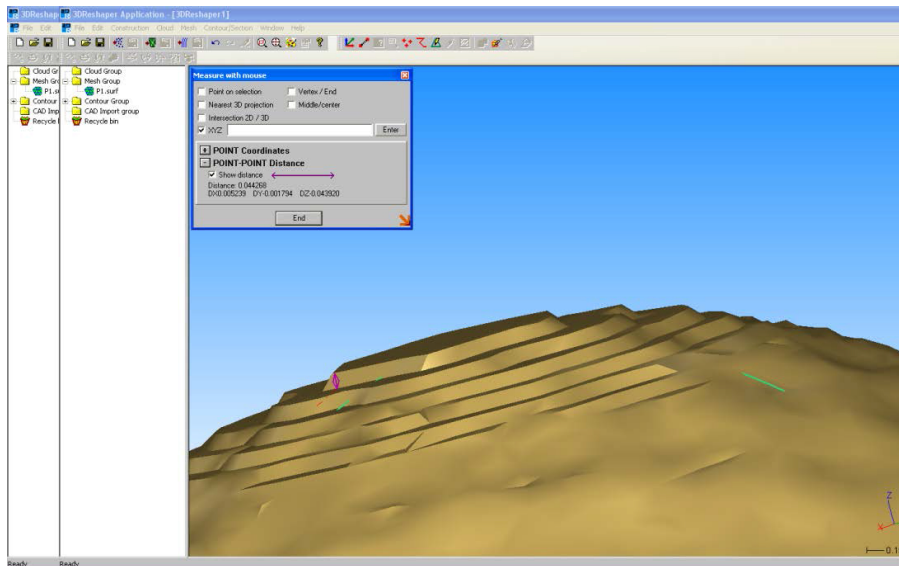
Tomography pole in the CT model of ceramic reference ball
